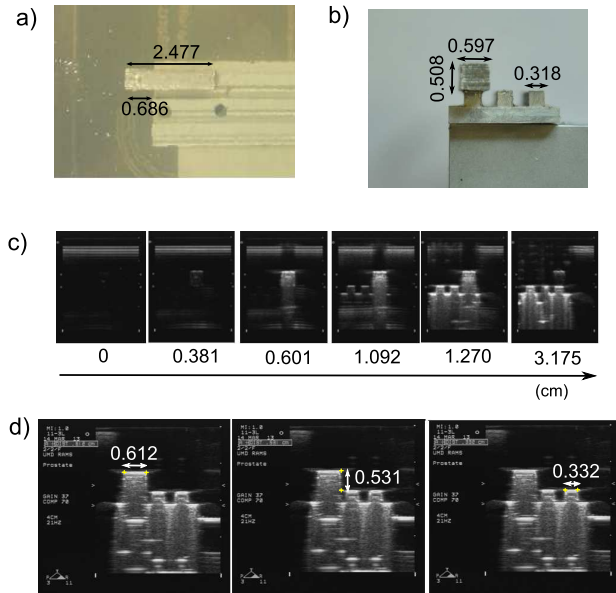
Ultrasound beam width and spatial resolution experiments: a) The top view of the object that was scanned with the transducer, b) The front view of the object that was scanned, c) the ultrasound images of the object at different positions along the scanning axis, d) the dimensions of the object that were measured using the ultrasound console. The dimensions are in cm.
